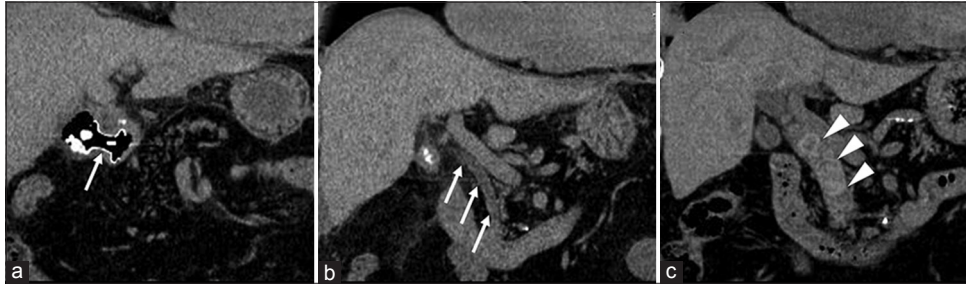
Computed tomography scan at the time of EUS-guided gallbladder drainage the lumen-apposing metal stent (arrow) (a) and no stones in the common bile duct (arrows) (b) computed tomography scan 4 years after EUS-guided gallbladder drainage showing many stones in the common bile duct (arrowheads) (c)
